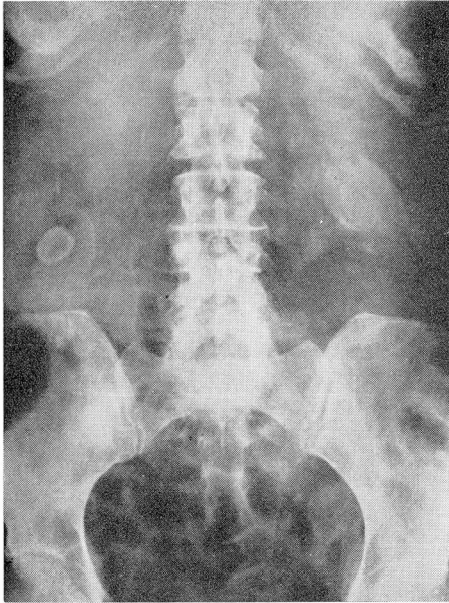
Postoperative roentgenogram showing gallbladder and right kidney returned to normal position.
